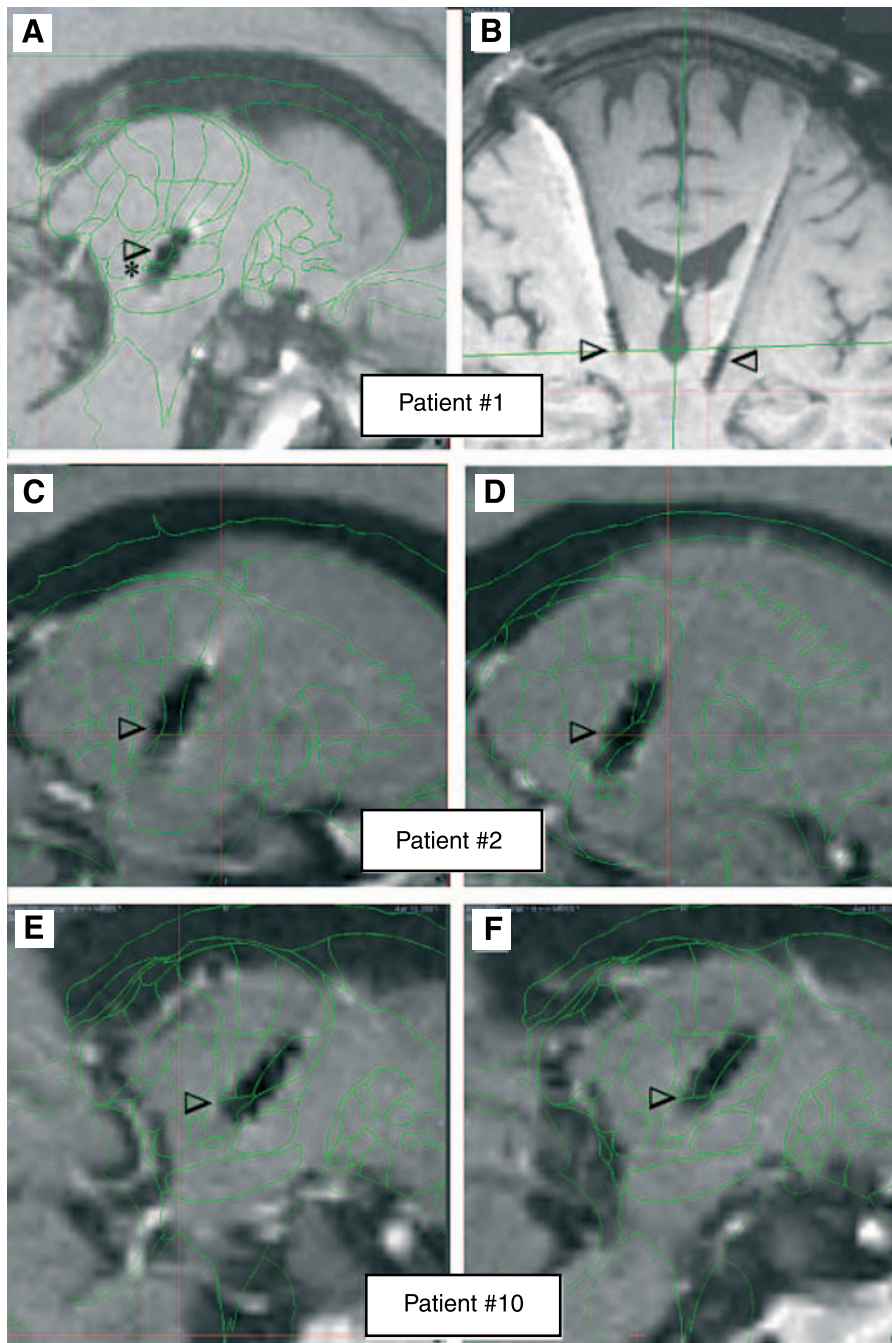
Assessment of DBS electrodes in postoperative MRI. (A) A sagittal reconstruction of the postoperative T1WI-MRI correlated with the Schaltenbrand and Wahren atlas (12 mm lateral) as described in Patients and methods. The artifacts of all four contacts of the left electrode can be distinguished. The active contact (arrowhead) resulting in best suppression of head and contralateral intention tremor projects into the subthalamic area in close vicinity to the zona incerta, the subthalamic nucleus, and the prelemniscal radiation (stereotactic coordinates relative to the mid-commissural point:  $x = -12.5$ ;  $y = -7.4$ ;  $z = -2.9$ ). The contact below (\*) was slightly more effective but associated with side effects. (B) An oblique coronal reconstruction along both electrodes of the same patient (number 1) is shown. All contacts of the asymmetrically placed electrodes can be distinguished. The left electrode was positioned more ventrally and medially. The green lines indicate the midsagittal and the horizontal planes crossing at the inter-commissural line. The tilt in the horizontal line is due to reconstruction of the image in order to depict both electrodes. Stimulation on the right side proved best with the lowest contact which is located at the base of ventralis intermedius (stereotactic coordinates relative to the mid-commissural point:  $x = 14.7$ ;  $y = -7.3$ ;  $z = 0.2$ ). (C–F) The active contacts (arrowheads) of the left (C) and right (D) electrode of another patient (number 2) project onto the base of nucleus ventralis intermedius and base of nucleus ventralis intermedius/subthalamic area, respectively. The stereotactic coordinates relative to the mid-commissural point are: *left*  $x = -14.2$ ,  $y = -7.0$ ,  $z = 0.1$ ; *right*  $x = 15.6$ ,  $y = -7.2$ ,  $z = -1.7$ . The same analysis in another patient (number 10; cf. Fig. 1) revealed both active contacts (E, left; F, right electrode) within the subthalamic area touching the base of nucleus ventralis intermedius. The stereotactic coordinates relative to the mid-commissural point are: *left*  $x = -10.9$ ,  $y = -6.8$ ,  $z = -1.8$ ; *right*  $x = 9.9$ ,  $y = -6.3$ ,  $z = -1.4$ .
